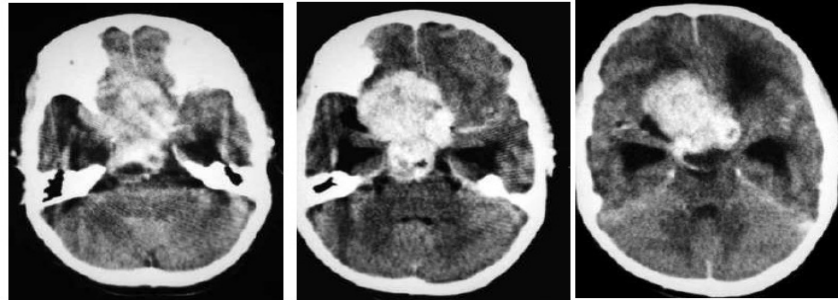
Axial post contrast images of CT scan shows heterogeneously enhancing sella and supra sellar mass
